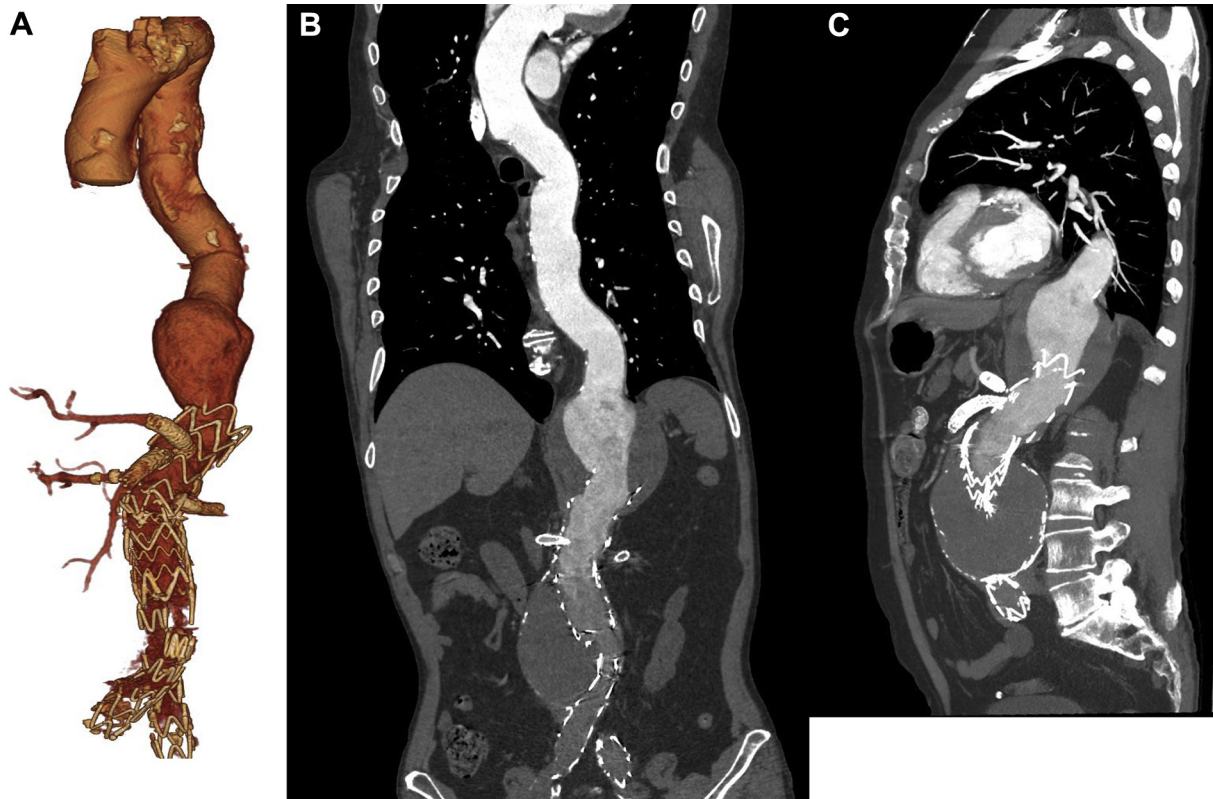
Three-dimensional volume-rendered reconstruction (A) and coronal (B) and sagittal (C) orientations of the preoperative computed tomography (CT) scan in 2018 showing an aneurysmal evolution of the distal thoracic aorta (DTA).
